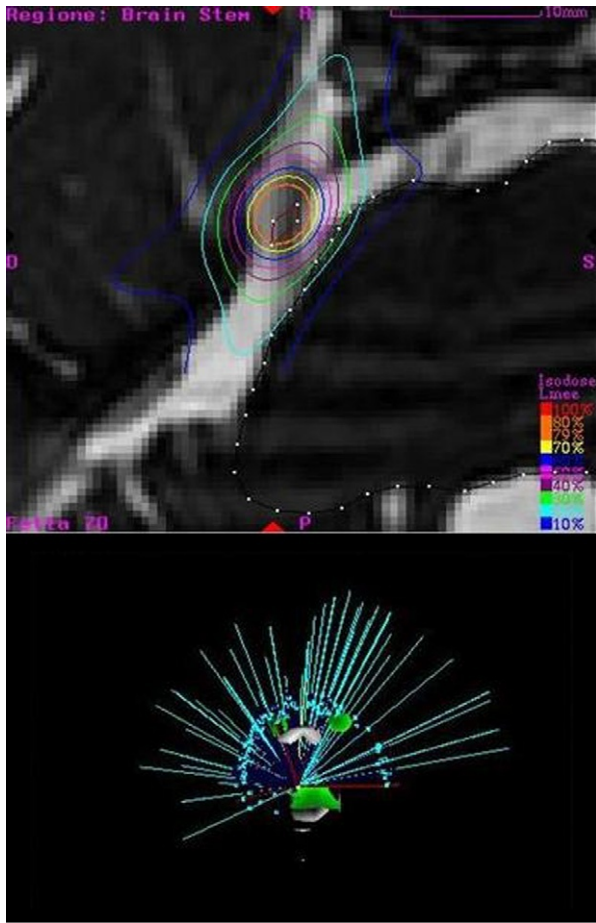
Isodose distribution comprising the entire intracranial course of the trigeminal nerve. Concentric isodose lines are also depicted in this T₂-weighted magnetic resonance imaging scan.
